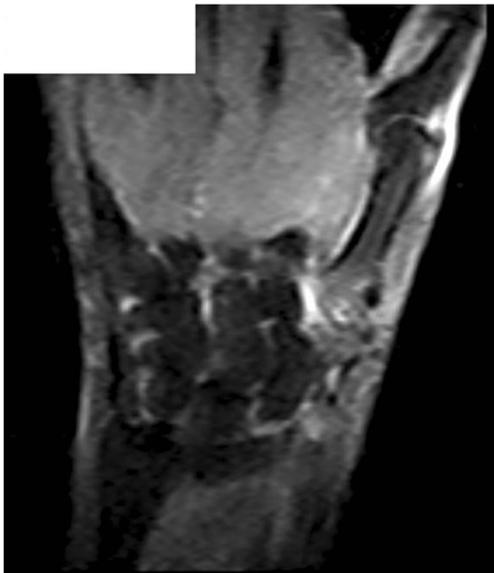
MRI at final follow-up of a patient treated with suspension arthroplasty
